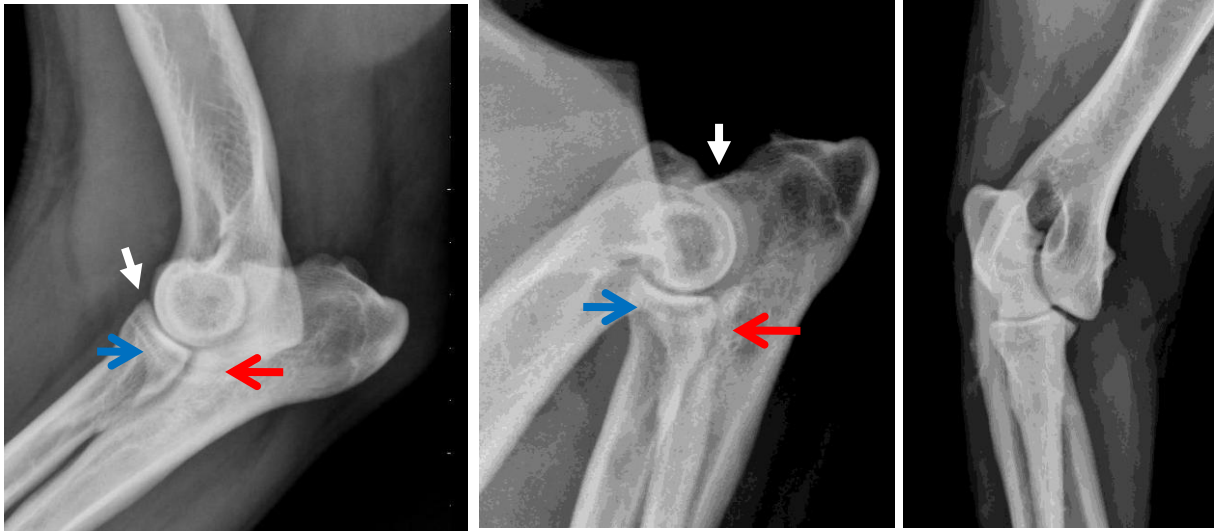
Extended-, flexed- and cranio-caudal-, oblique view of the left elbow. Minimal periosteal reaction on the anconeal process and cranial part of the radius is visible (white arrows). Moderate sclerosis in the ulnar area, caudal of the radial head is present (red arrow). The processus coronoideus medialis is showing an unsharp delineation and looks less dense than normal. These radiographic signs are compatible with coronoid disease.
